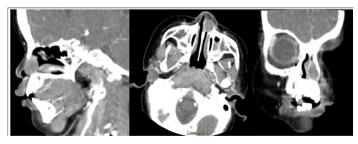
Case 1 is an 12-month-old female who presented with nasal congestion secondary to an enlarging nasal mass. CT of the maxillofacial area with intravenous contrast revealed a mildly enhancing 1.2 cm x 1.2 cm soft tissue mass in the left anterior nare. The mass abutted the anterior nasal septum medially and the frontal process of the maxilla and nasal bone laterally. Posteriorly, it is continuous with the left inferior turbinate. There is no evidence of destruction of the nasal bone or nasal septum. These findings are suggestive of a benign mass, such as a nasal polyp or intranasal glioma. Pathology following excisional biopsy revealed RDD.
